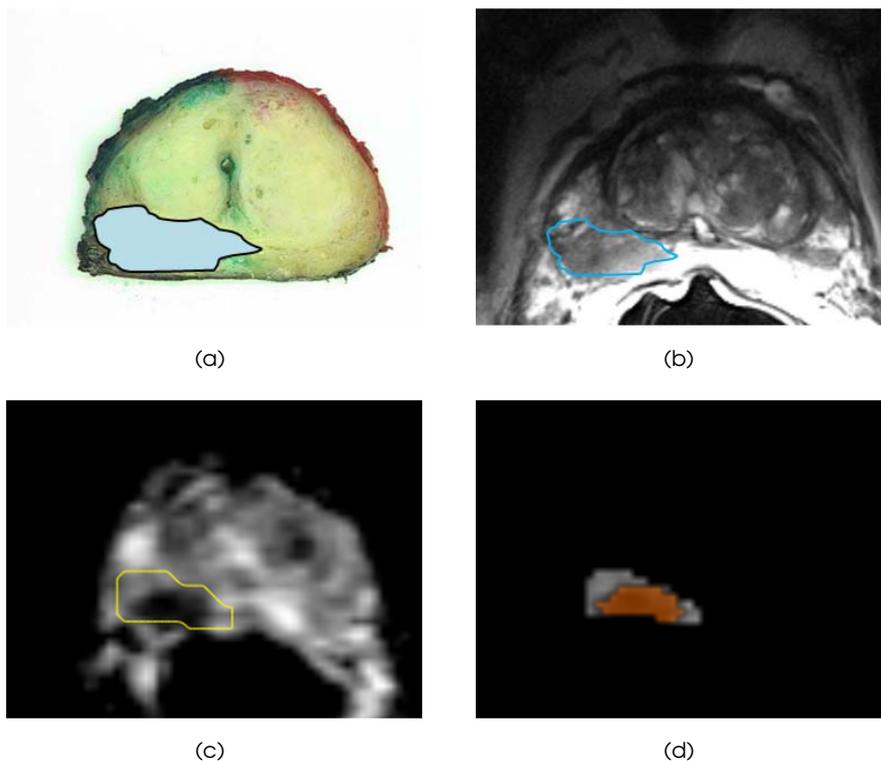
Patient with a peripheral zone tumour revealing Gleason 4 + 3 (+5) on final pathology. (a) Prostatectomy step section with the tumour delineated in light blue. (b) Anatomical T2-weighted MR image. A large tumour region corresponding to the step section is seen in the peripheral zone (blue delineation). (c) On the ADC map, water restriction is clearly visible for the same lesion. Regions of interest are annotated on the smoothed ADC map in correspondence with the prostatectomy step section (yellow delineation). (d) The segmentation of the focal finding based on ADC values (orange region). A seeded region growing was applied to detect a cluster of low ADC values within the tumour outline.
